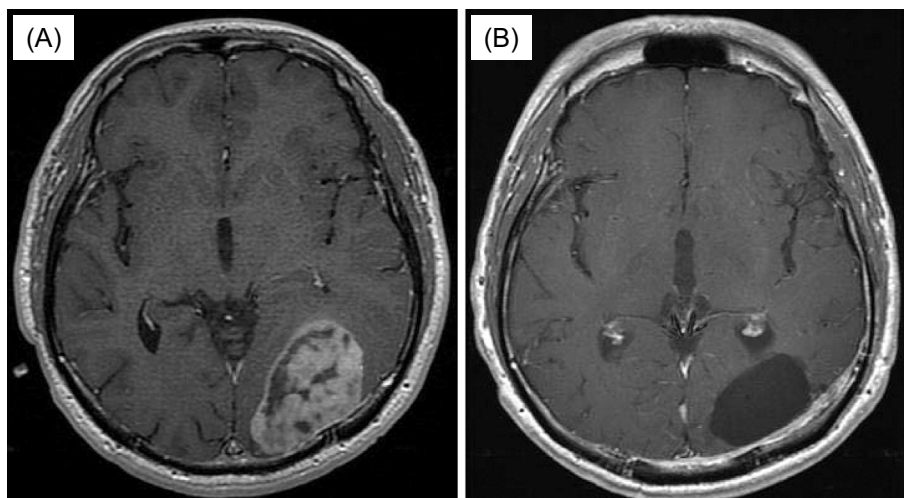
Contrast-enhanced brain MRI findings. (A) A large ring-enhanced tumor with intratumoral hemorrhage and peripheral edema in the left occipital lobe was seen at the time of the development of visual field disturbance. (B) The brain tumor disappeared after brain tumor resection and radiotherapy.
